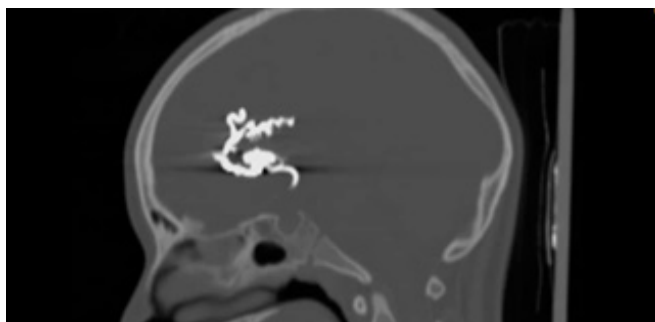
Angio-CT showing an embolized subcallosal artery.
